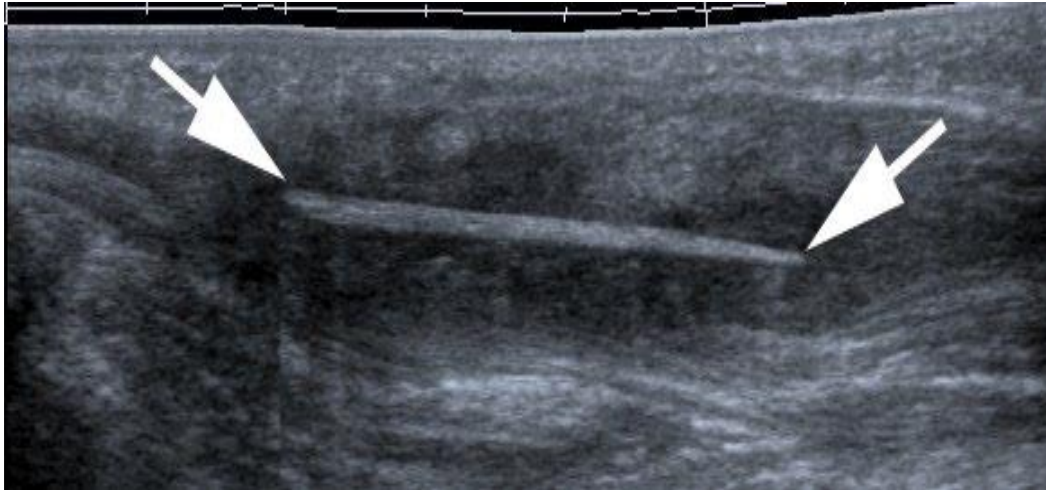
Echogenic FB within the plantar fascia. Image adapted from a study by Claire Filippini, 2019 on Ultrasound features of the sole of foot pathology (14)
